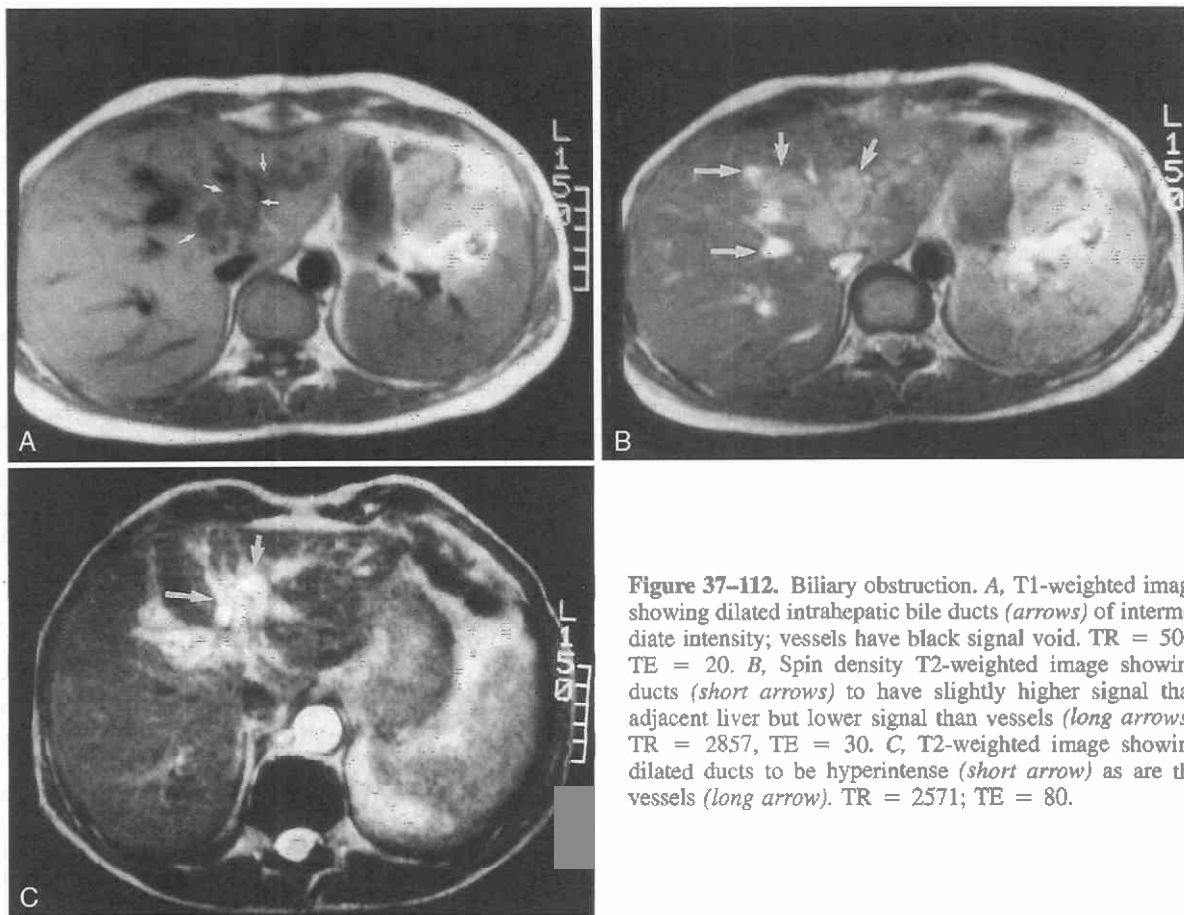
Biliary obstruction. A, T1-weighted image showing dilated intrahepatic bile ducts (arrows) of intermediate intensity; vessels have black signal void. TR = 500; TE = 20. B, Spin density T2-weighted image showing dilated ducts (short arrows) to have slightly higher signal than adjacent liver but lower signal than vessels (long arrows). TR = 2857, TE = 30. C, T2-weighted image showing dilated ducts to be hyperintense (short arrow) as are the vessels (long arrow). TR = 2571; TE = 80.
